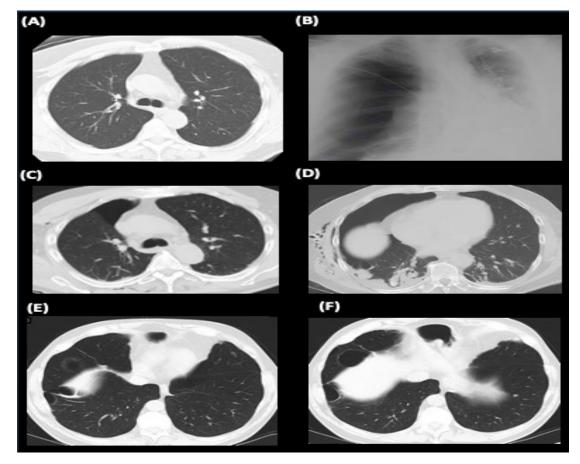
Case two. (A) Chest CT taken six years prior to presentation for pulmonary nodule follow-up. No bullae were visible at the time. (B) Chest radiograph taken at admission showing the right-sided pneumothorax. (C-D) Chest CT taken at admission showing pneumothorax with bulla visible in the right lower lobe in (D). (E-F) Follow-up chest CT images taken two months after initial presentation showing multiple right lower lobe bullae.
